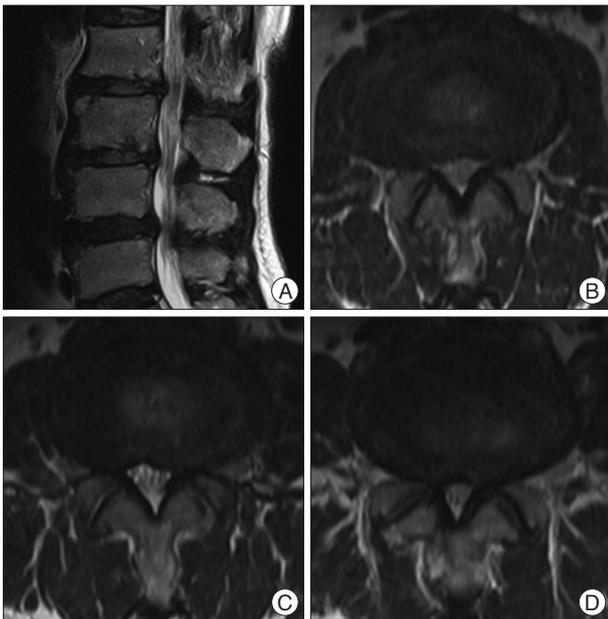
Magnetic resonance imaging of the lumbar spine. A : Sagittal T2-weighted image shows lumbar spinal stenosis at L2-L3, L3-L4, and L4-L5 level. B : Axial T2-weighted image at L2-L3 level shows central canal stenosis and bilateral neural foraminal stenosis. C : Axial T2-weighted image at L3-L4 level shows central canal stenosis, bilateral neural foraminal stenosis, and disc herniation to the left side of the thecal sac. D : Axial T2-weighted image at L4-L5 level shows central canal stenosis and bilateral neural foraminal stenosis.
